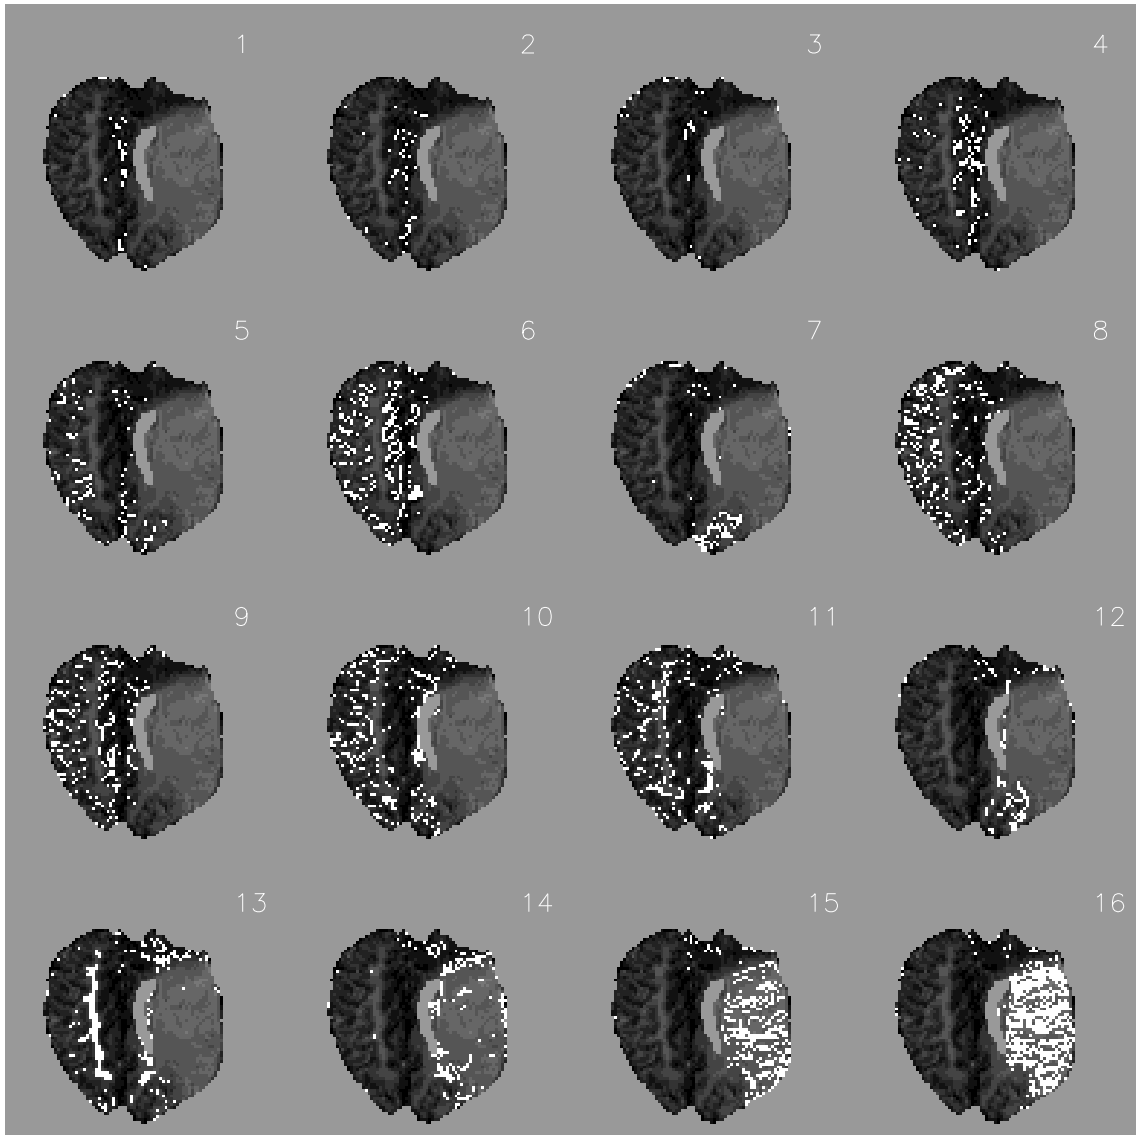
Cluster assignment maps for minimal free energy vector quantization of a dynamic perfusion MRI study in a patient with a large stroke in the supply region of the left middle cerebral artery.
